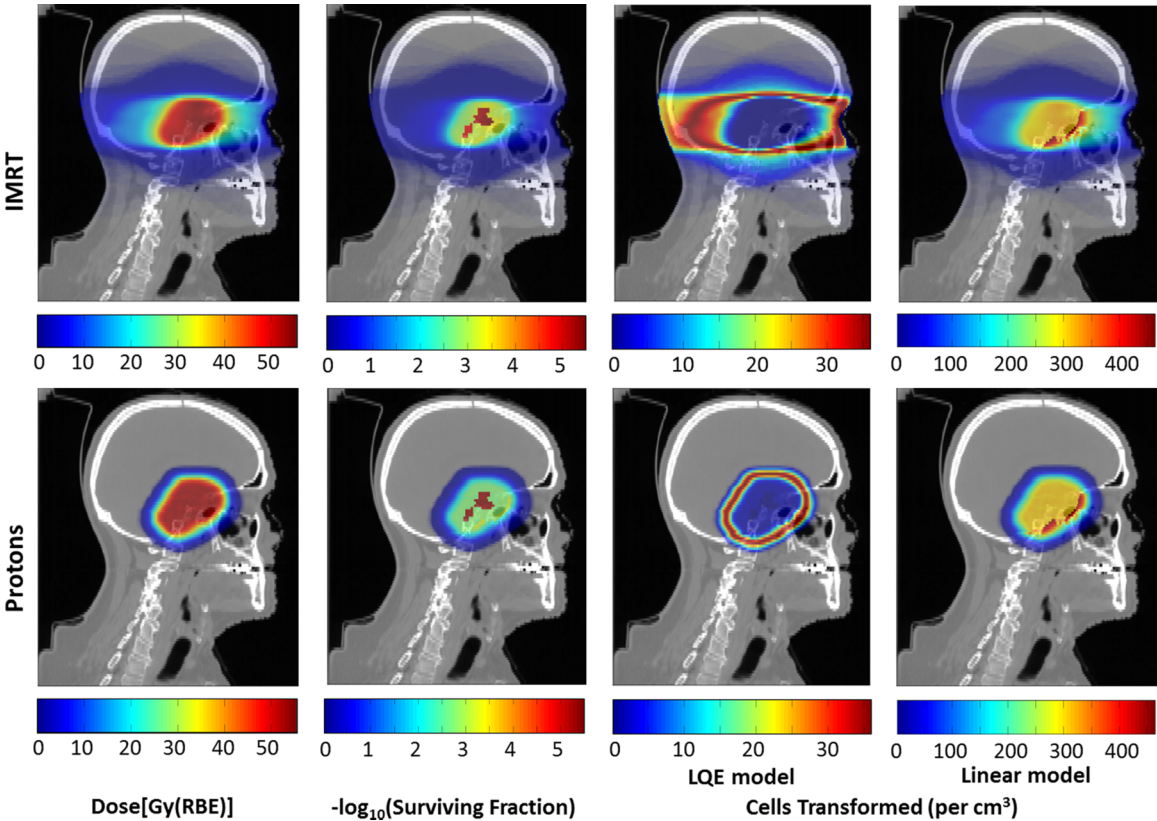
2D maps of dose, surviving fraction, and expected number of cells transformed [for both the LQE model and the linear (L) model] in the intensity-modulated x-ray and proton treatments of a subtotaly resected meningioma. Note that the transformed cell densities apply to radiation-induced premalignant cell damage, which is much more prevalent than observed clinical malignancies, and the color bars for LQE and L models have different scales. The maps shown are sagittal slices through the centre of the GTV and the color washes fade out for doses lower than 1% of maximum dose. RBE = 1.1 for the proton plan and 1.0 for the IMRT plan.
